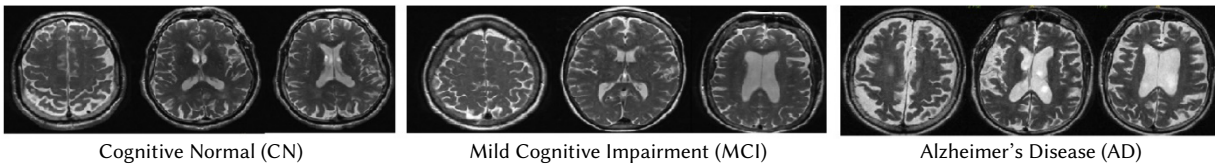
Cross-sections from MRI images of CN, MCI, and AD.
